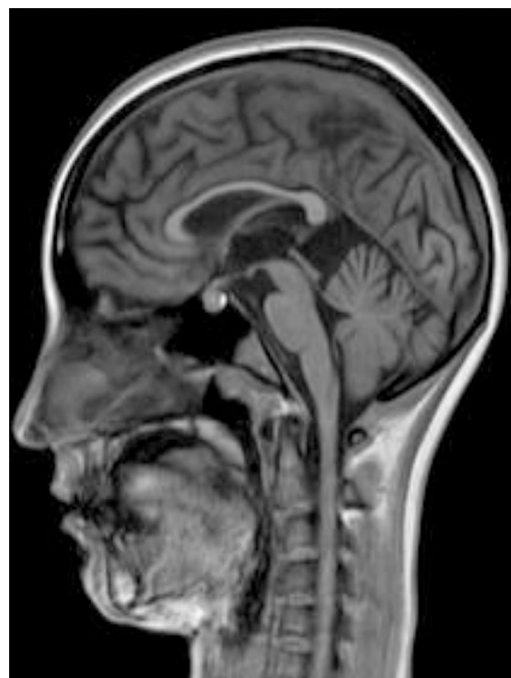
Patient 2. T1-weighted TSE sequence revealing slight thinning of the corpus callosum.
